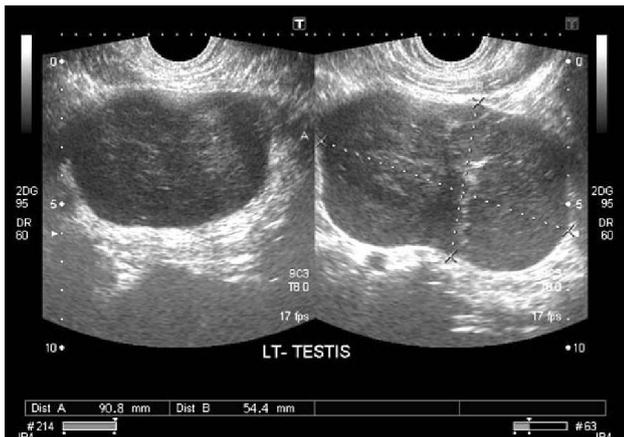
Ultrasound showing left undescended testis, seen in left side of pelvis, it is enlarged in size, the entire parenchyma replaced by multiple hypochoic mass lesions
